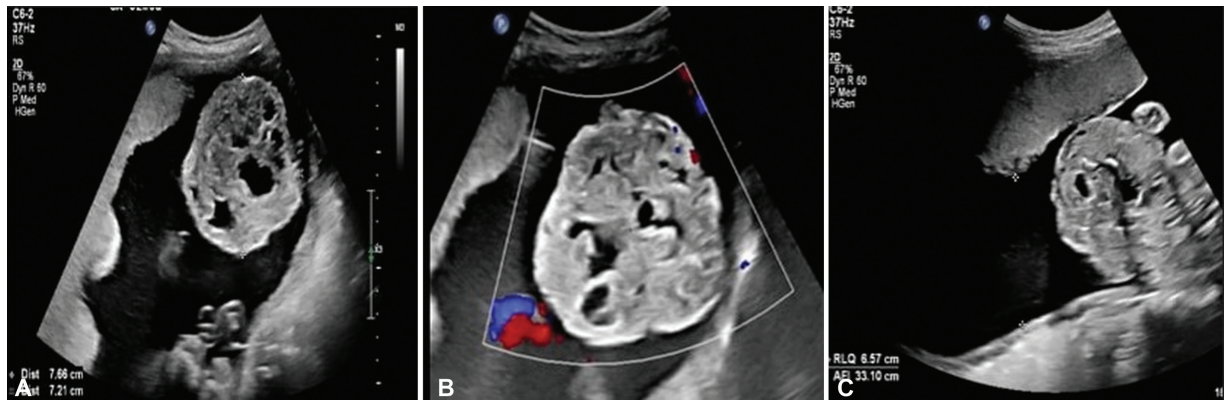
Ultrasound done at 26 weeks showing (A) heterogenous mass of 7.66 × 7.21 cm with solid cystic areas and (B) minimal internal vascularity associated with (C) polyhydramnios (AFI: 33 cm).
